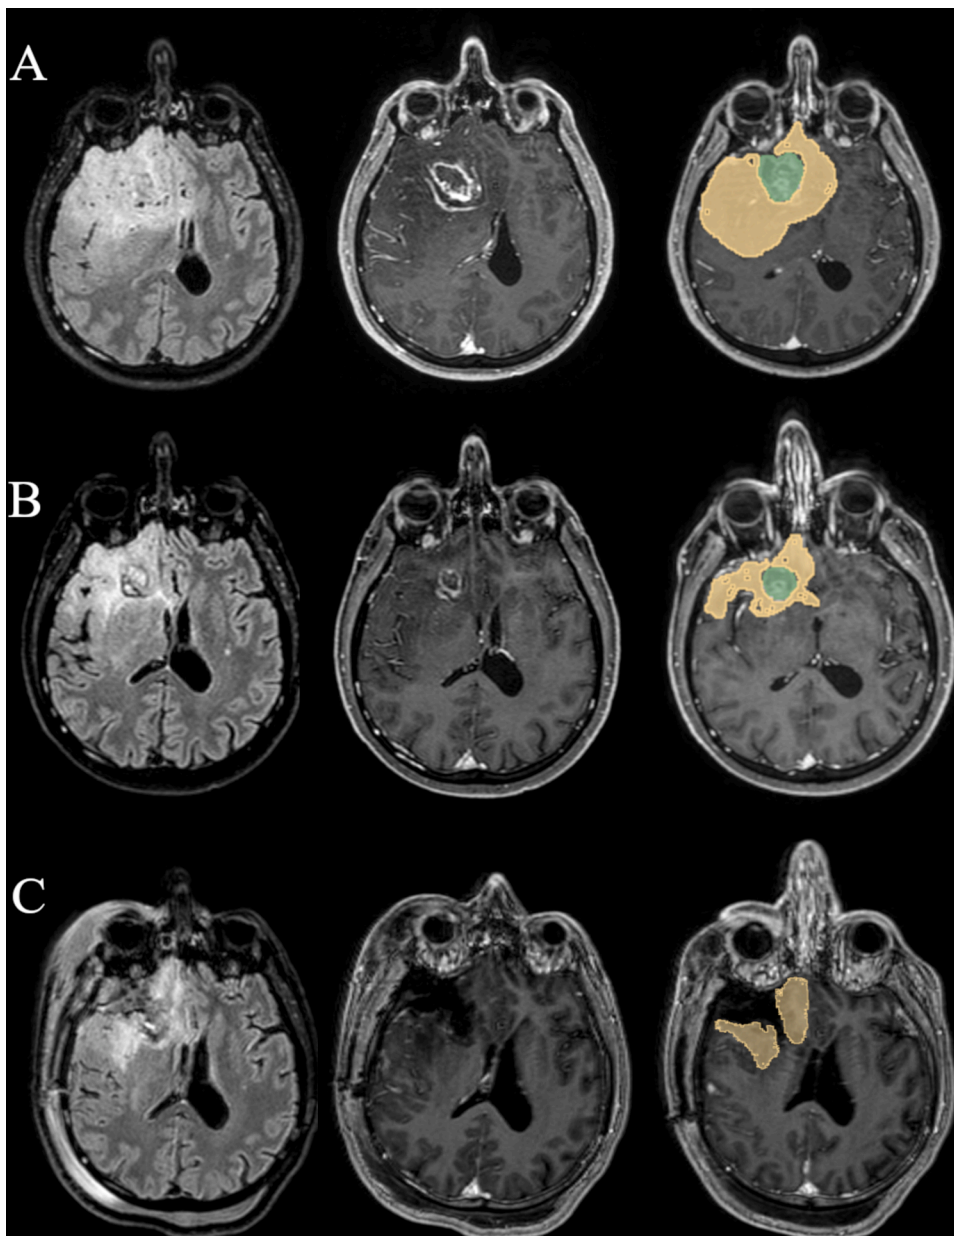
Row A. MRI shows a voluminous infiltrating lesion in the right fronto-insulo-temporal site. Evidence of wide perilesional edema (FLAIR sequence, on the left); a fronto-basal nodule with cystic-necrotic areas in the context of the lesion (T1-weighted sequence with Gadolinium, in the middle); tumor volume before neo-adjuvant treatment (on the right). The lesion displaces the ventricular system to the left. Row B. MRI after neo-adjuvant treatment with Silibin. Evidence of a clear reduction in tumor volume (on the right), both in the enhancing core (T1-weighted sequence with Gadolinium, in the middle) and inner the infiltrating area, visible in FLAIR (on the left). A clear reduction of the peritumoral edema and of the dislocation of the ventricular system was also observed. Row C. Brain MRI was performed 24 h after surgery and documented a gross resection of the tumor.
